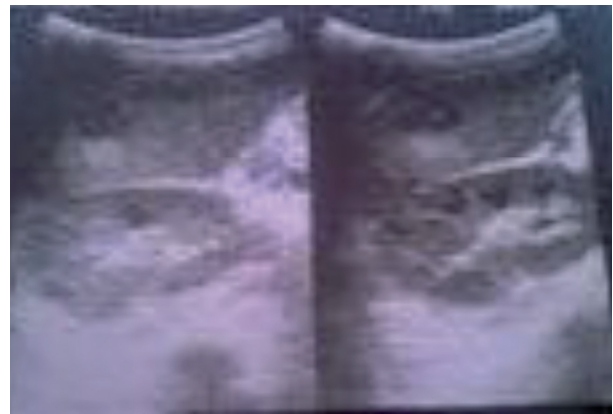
Ultrasound imaging of the largest liver abscess, 1,7 cm in diameter.
